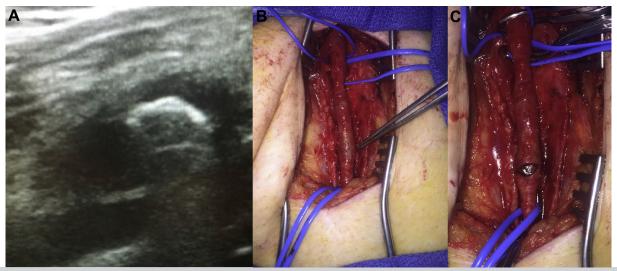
A, Ultrasound revealing hyperechoic foreign body in the superficial femoral artery (SFA). B, Exposure of left common femoral artery, SFA, and profunda femoris artery with intraluminal mass in SFA (forceps). C, Transverse arteriotomy demonstrating bullet embolus in the SFA.
